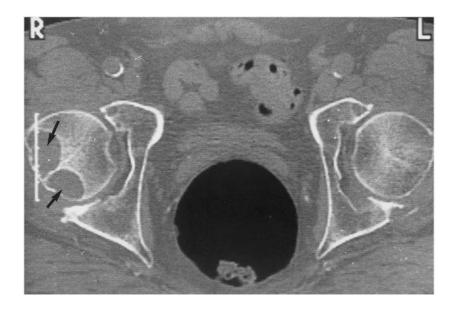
Computed tomography (CT) scan of the hip. The arrow indicates amyloid erosions of the right femur. Reproduced with permission from Bardin et al. [112].
